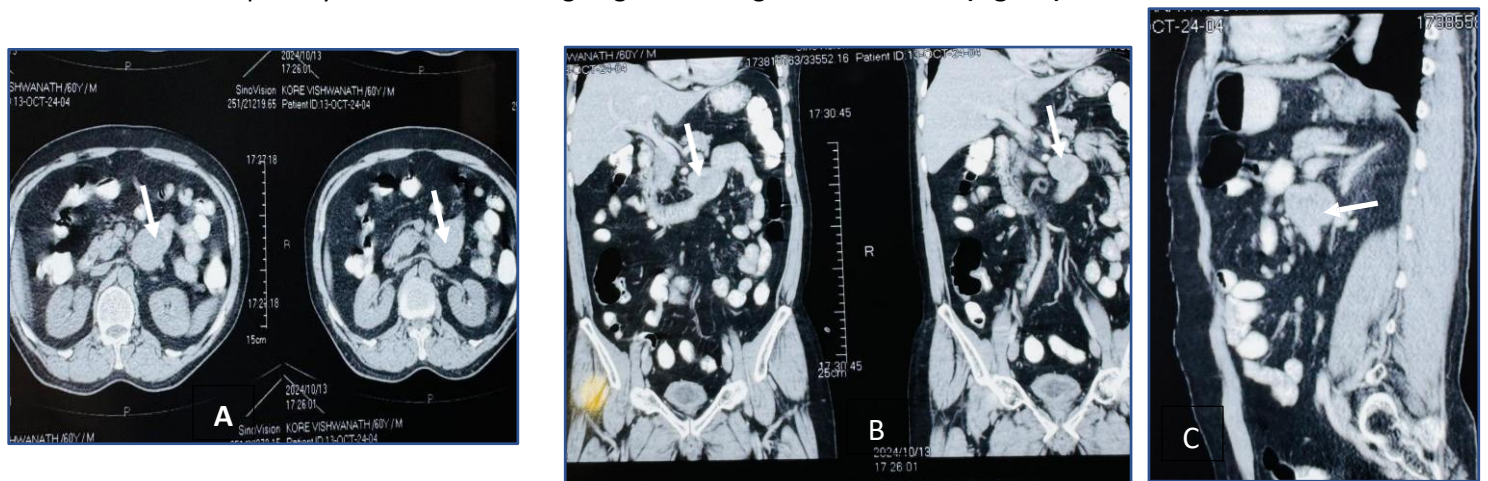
A – axis view, B- Coronal view, C- Sagittal view CT abdomen showing a proximal jejunal soft tissue mass, measuring 4.6x3.5cm.
